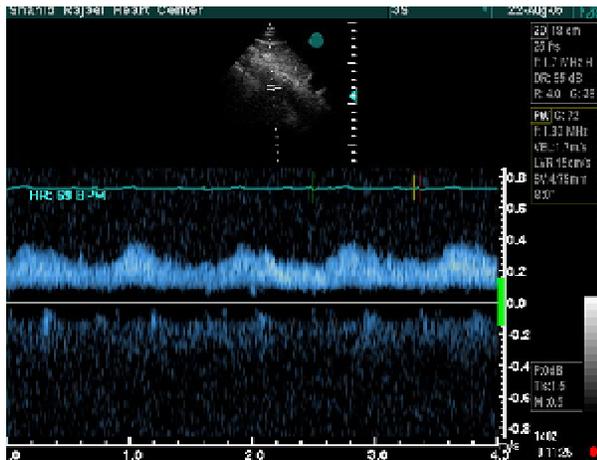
Abdominal aortic pulsed wave Doppler signal showing holodiastolic antegrade flow
